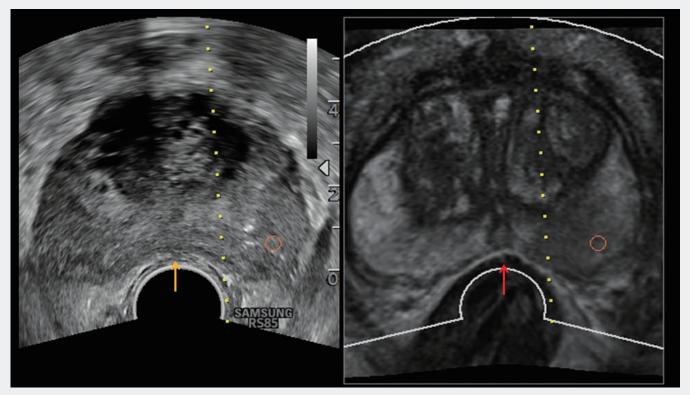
Same patient as Figure 8. The deformation correction algorithm on the system improve the accuracy of registration by correcting the deformed prostate MRI shape (red arrow) when transducer is compressed the prostate tissue (yellow arrow).
